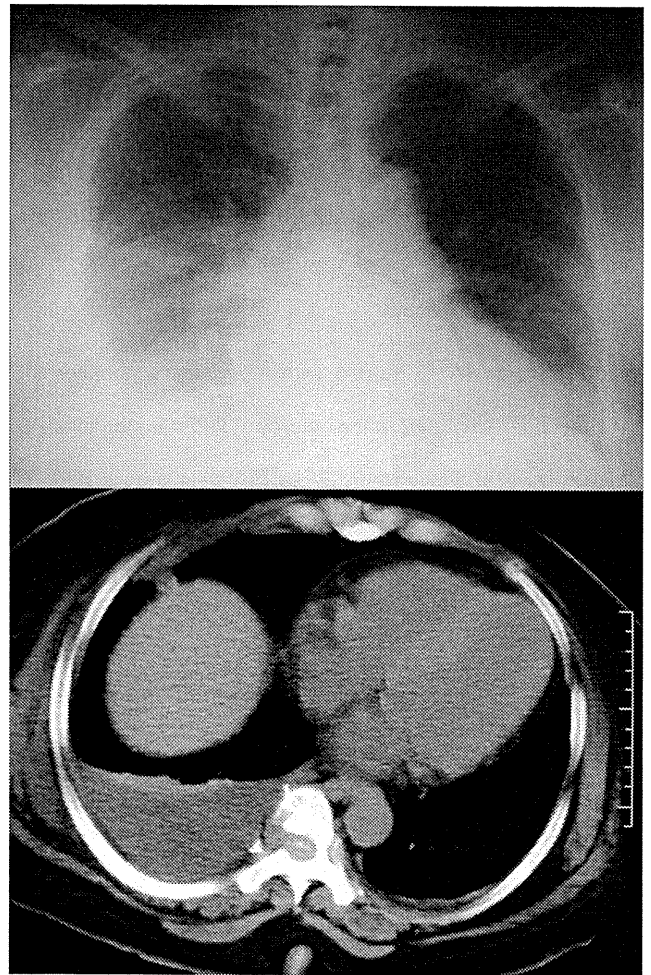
Postoperative plain chest radiograph (top) and CT (bottom) of case 1 on day 20 revealed massive collection of cerebrospinal fluid in the right pleural cavity.
